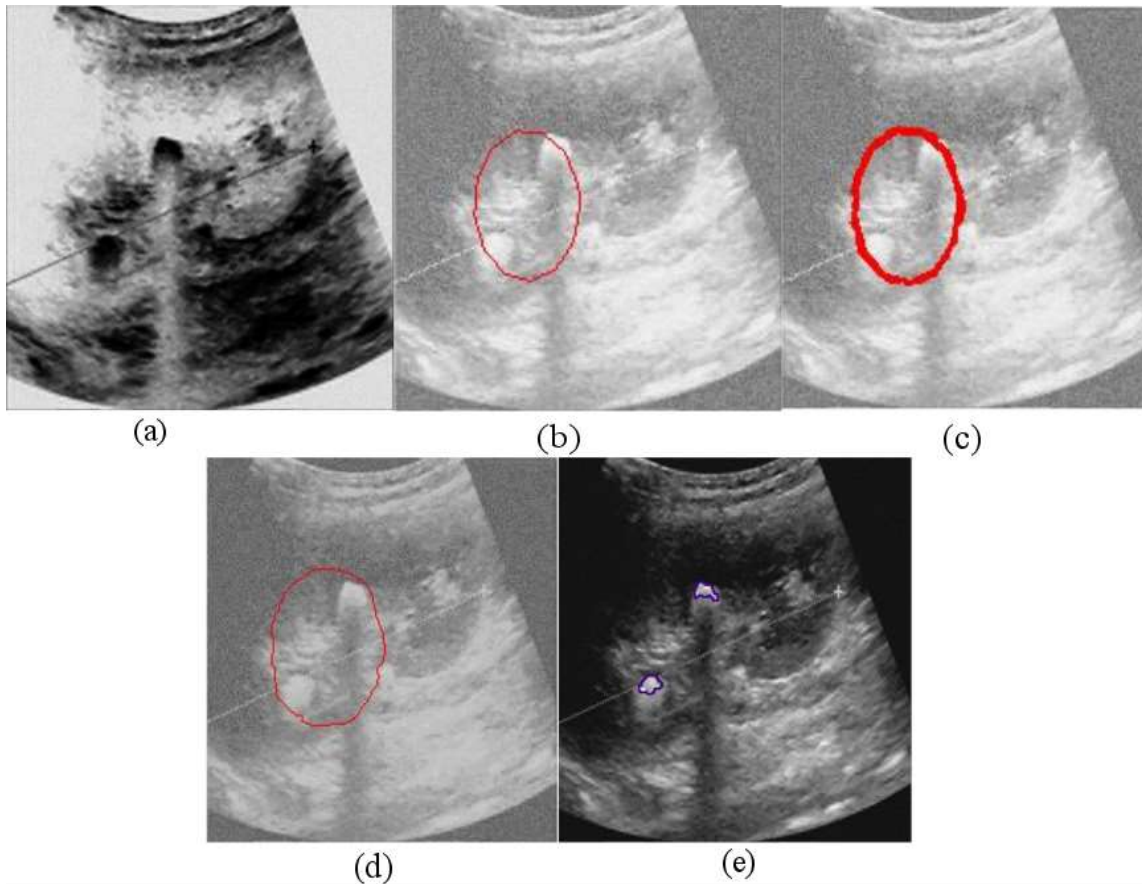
Segmentation of multiple-stones kidney using GVF model: (a) Denoised multiple-stones ultrasound image of the kidney (b) Predefined Initial contour (c) Deformed intermediate image (d) Finally segmented image (e) Manual annotation by medical expert
